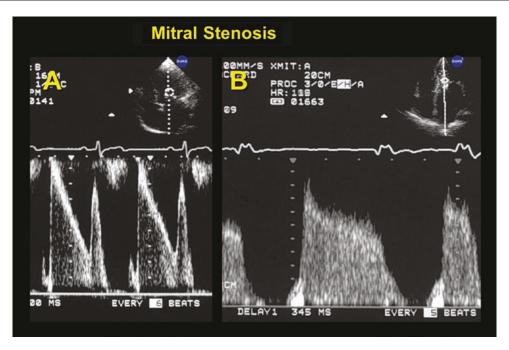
Spectral Doppler recordings from the apex showing normal mitral diastolic flow compared to mitral stenosis. In mitral stenosis there is spectral broadening and a slow diastolic flow decay
